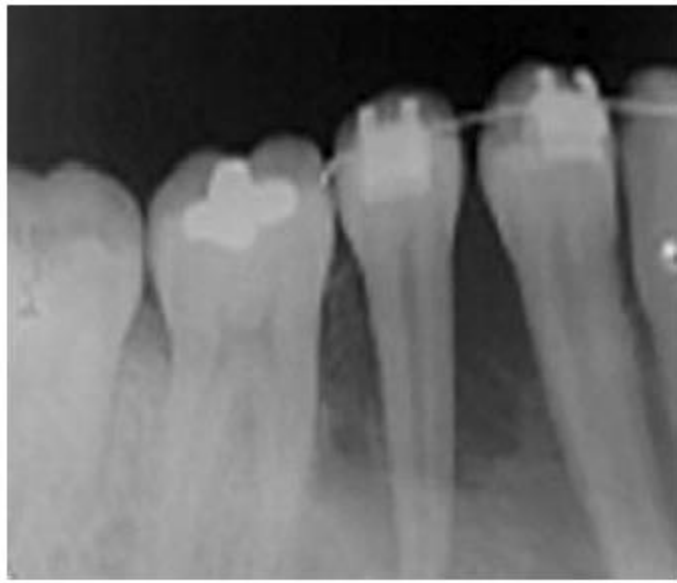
Initial orthopantomography examination (June, 2001). The radiograph displayed a mild radiolucent lesion involving the right mandibular second premolar.
